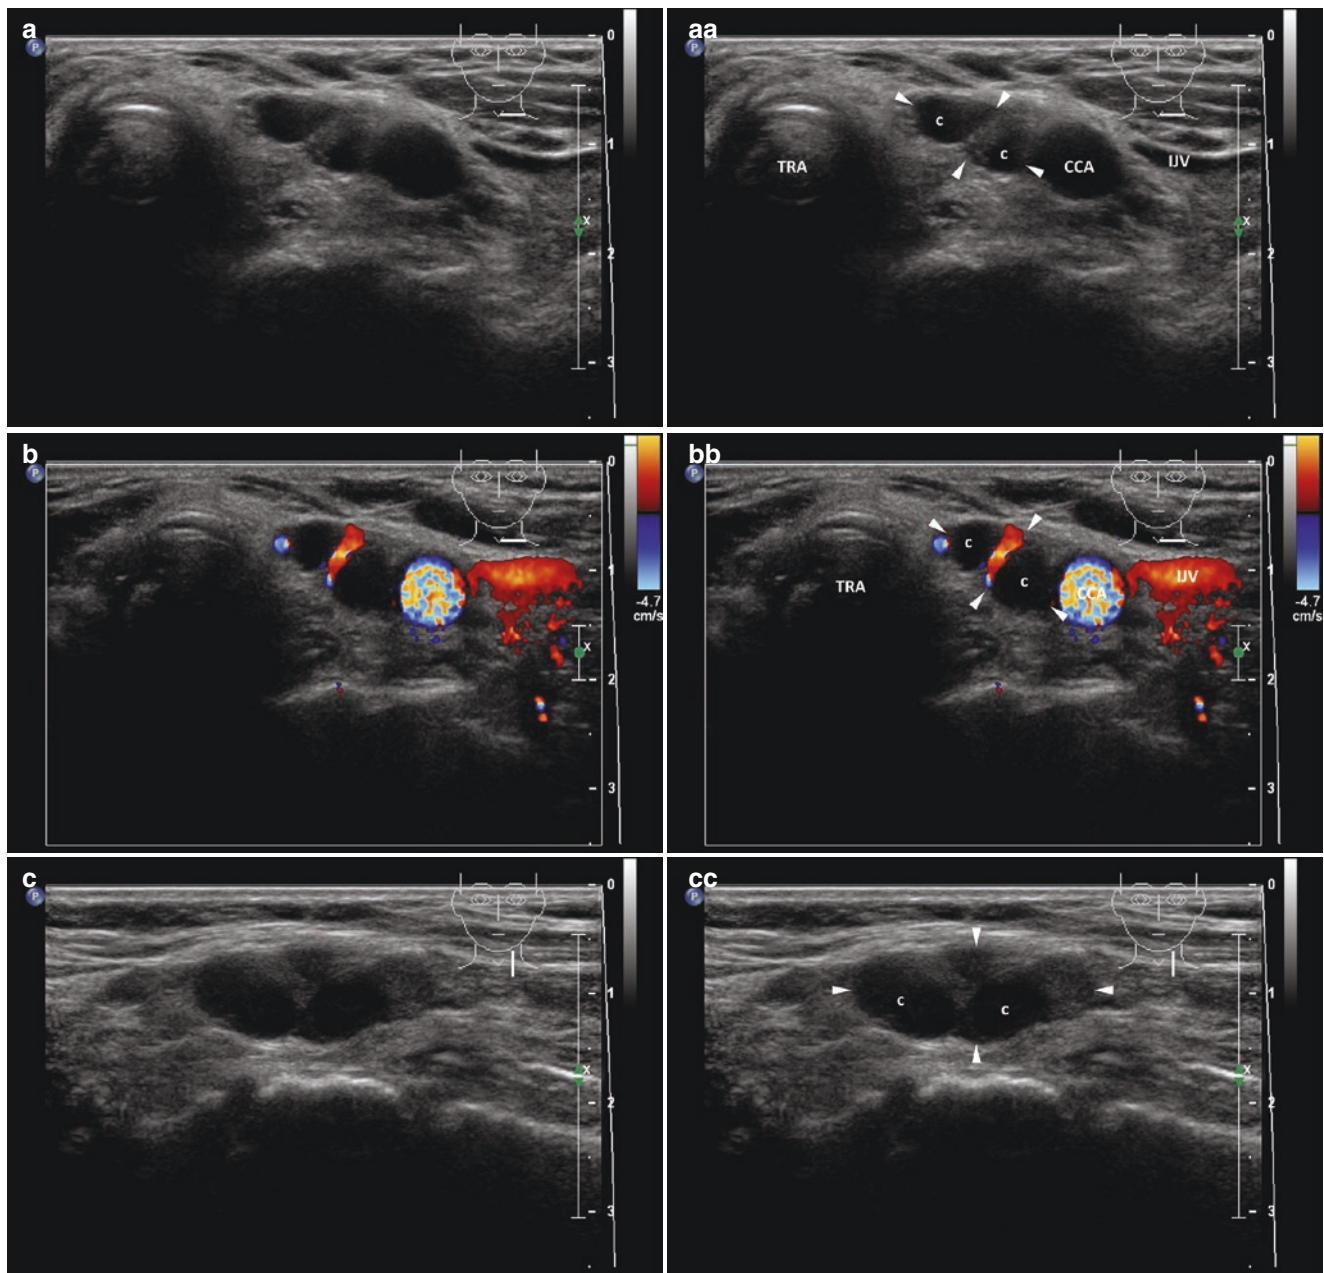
(aa) A 61-year-old woman, end stage kidney disease on renal replacement treatment with sHPT, laboratory: mild hypercalcemia, s-Ca 2.63 mmol/L (normal: 2.15–2.55), high level of parathyroid hormone, s-PTH 314 ng/L (normal: 12–65), urea 19.8 mmol/L, creatinine 192 μ mol/L. Personal history: diabetes mellitus type 2, coronary artery heart disease with paroxysmal atrial fibrillation, 30 years post subtotal thyroidectomy for benign multinodular goiter, 16 years post total thyroidectomy of remnants and 5 years post parathyroidectomy on the right side. New lesion in the left thyroid bed—left parathyroid adenoma (PAD) with degenerative changes, size 24 \times 12 \times 7 mm and volume 1 mL; confirmed by 99m Tc-MIBI scintigraphy. US scan prior to PEIT, PAD (arrowheads) located in left thyroid bed: bean-like shape; inhomogeneous structure; two cystic cavities (c) and thick hyperechoic septum in the middle part; transverse. (bb) Detail of left PAD (arrowheads), CFDS: hilar vascularity and vessel in septum; transverse. (cc) Detail of left PAD (arrowheads): two cystic cavities (c) and thick hyperechoic septum in the middle part; longitudinal.
